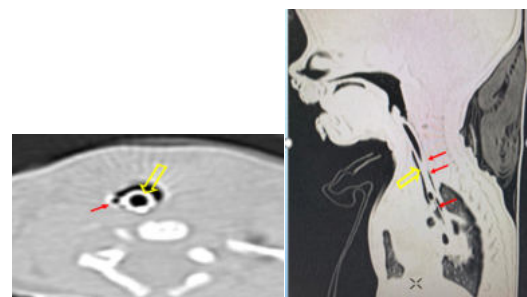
CT axial showing the nasogastric tube (red arrow) and the endotracheal tube (yellow arrow) side by side in the proximal dilated esophagus. The trachea is absent.
